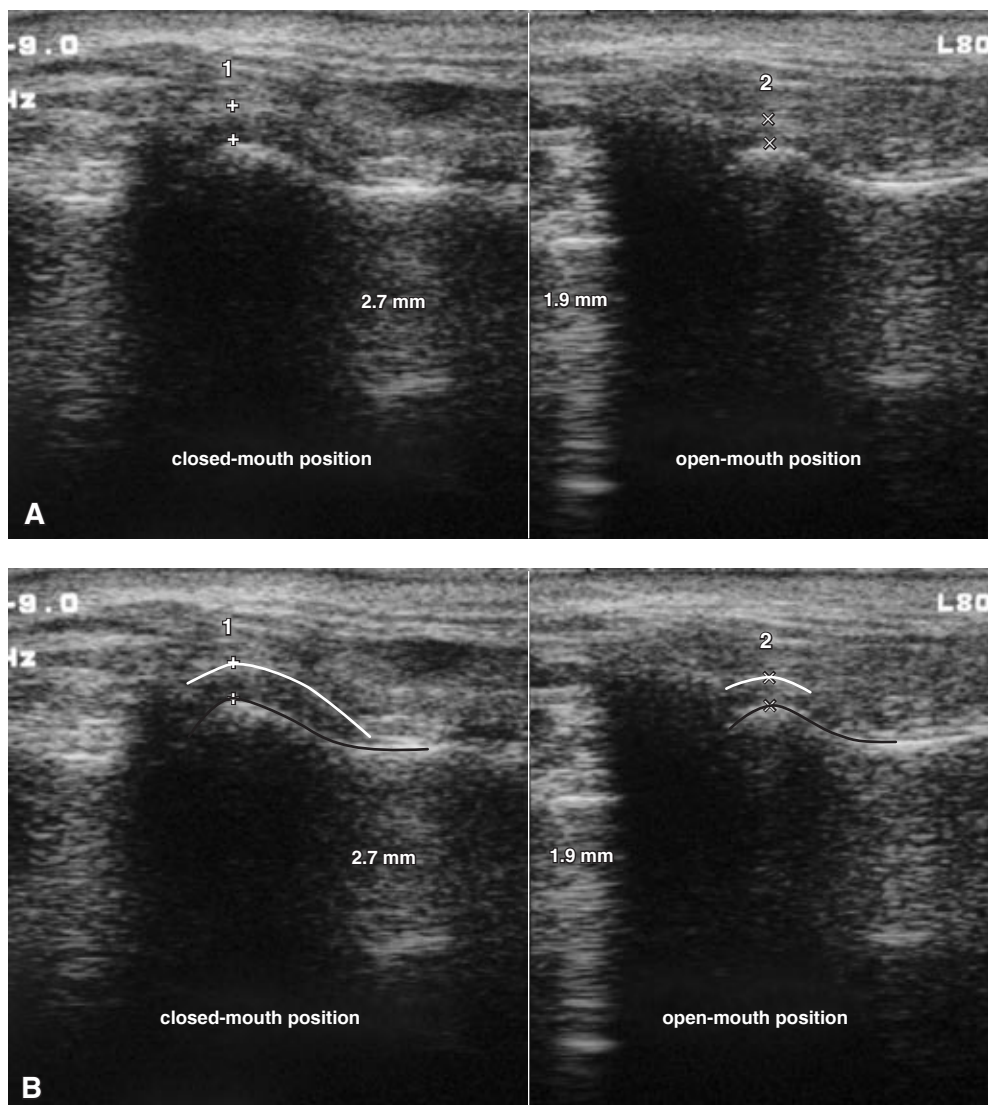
A) Lateral capsule-condyle distance, as seen in a longitudinal (coronal) ultrasonographic scan, in the closed-mouth position (1 = 2.7 mm) and open-mouth position (2 = 1.9 mm). The top of the figure is guided to lateral and the left side to superior.
